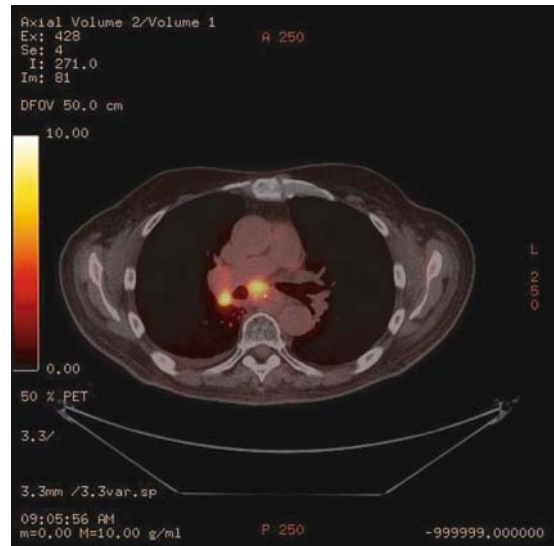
PET/CT demonstrating regional lymph node involvement in the right peribronchial region
